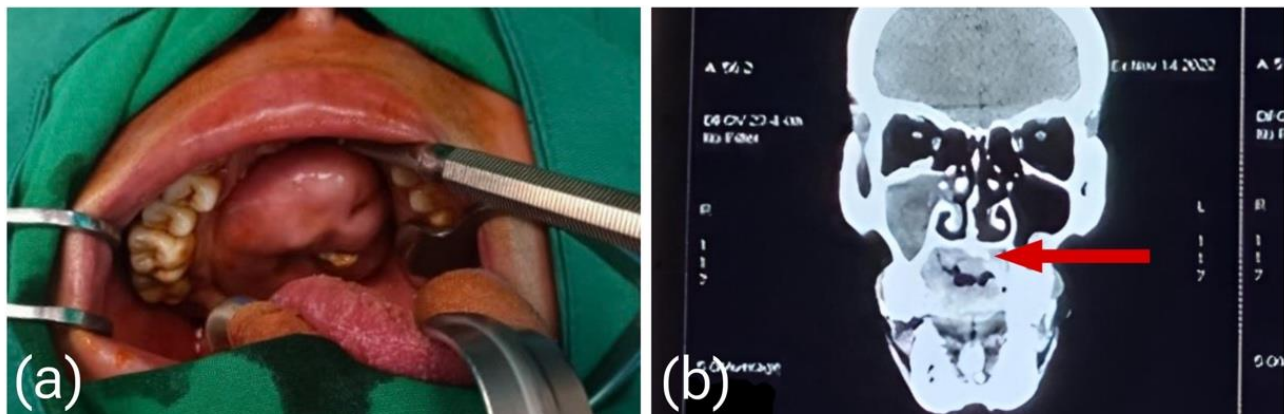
(a) Clinical view of palatal pleomorphic adenoma, (b) CT-Scan examination.
